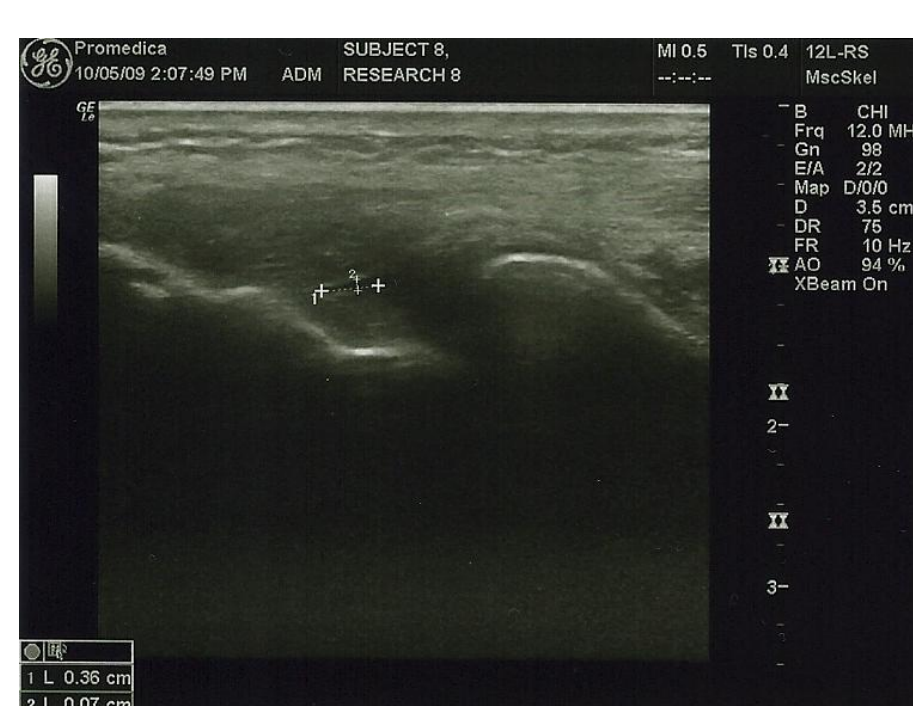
An example of a pre-treatment sonogram
